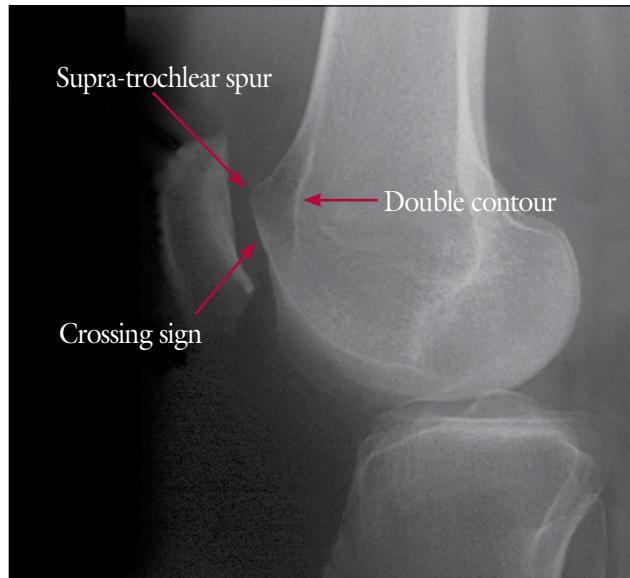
X-ray detection of typical indication for trochleoplasty
